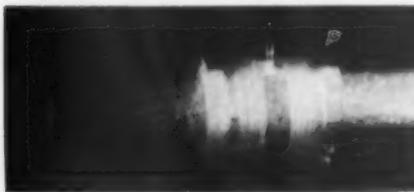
Similar to figure 6 but showing in addition elimination of reflection of ultrasound.
